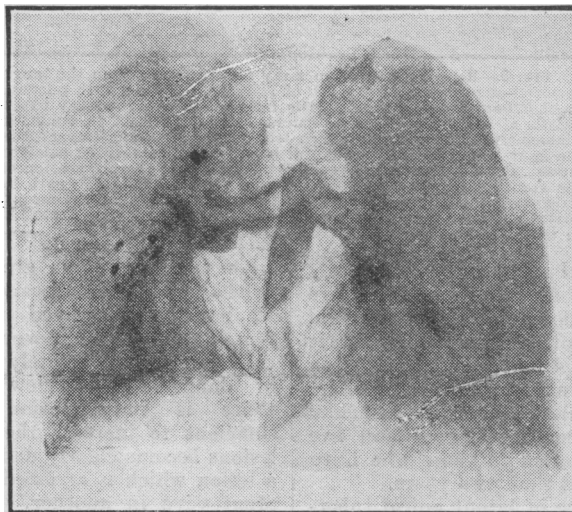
Reproduction of an x-ray film prepared from the lungs of a boy aged 13, showing latent apical tuberculosis on the right side (reversed in the figure) and calcified nodules in the lung and adjacent lymph nodes on the left side. Death occurred as the result of peritonitis following laparotomy. At the right apex in continuity with the puckered pleura there was fibrous and caseous tissue forming a mass 3 cm. across. In the left upper lobe there was a small calcified nodule and larger firmly calcified nodules in lymph nodes at the hilum of the lobe. In the substance of the left lower lobe and in adjacent lymph nodes there were similar lesions.
